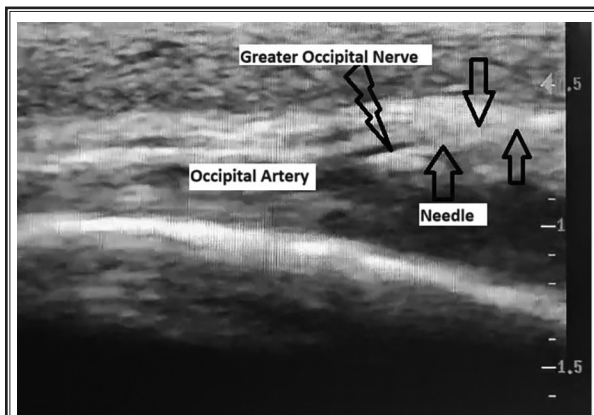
Ultrasound image obtained with a high frequency probe showing “in-plane” needle insertion with the tip resting adjacent to the occipital artery.
